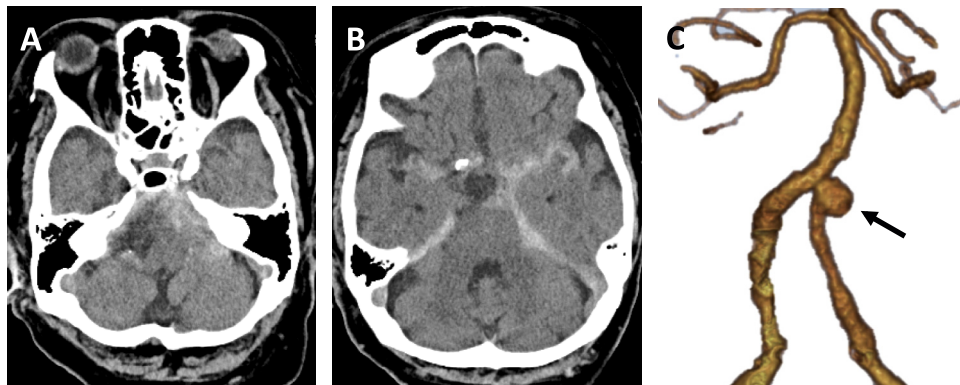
(A and B) CT images on admission showed diffuse subarachnoid hemorrhage predominantly in the left cerebellopontine angle cistern. (C) CT angiography demonstrated a saccular aneurysm located at the vertebrobasilar junction (arrow). Abbreviation: CT, computed tomography.
